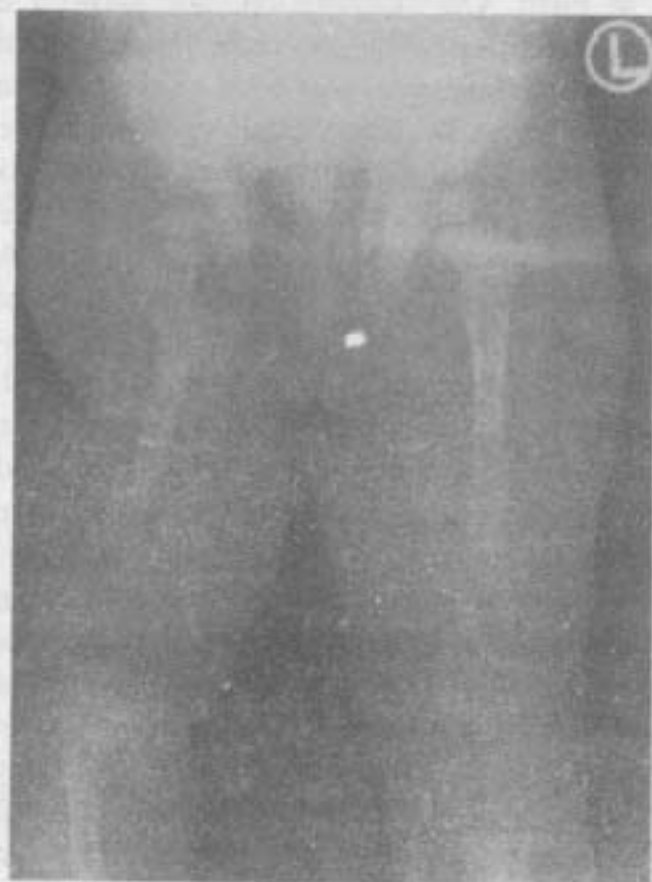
Radiograph showing deformity and shortening of right femur at 1½ years of age.
